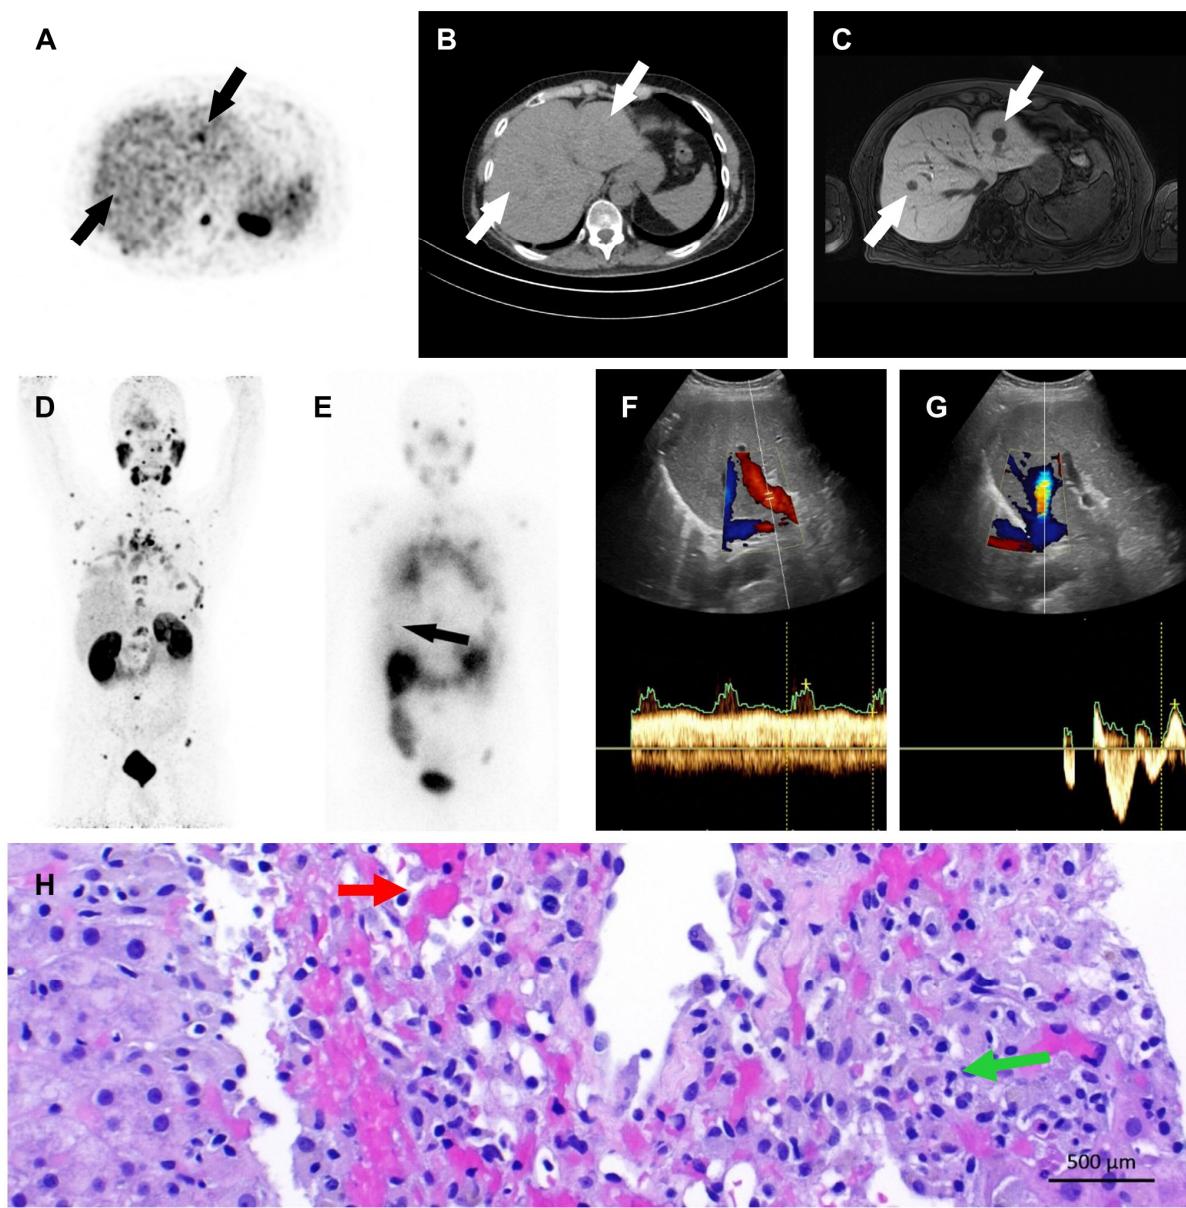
(A)-(C): Axial views of liver lesions: ^{68}Ga -PSMA PET/CT, contrast enhanced CT and MRI (T1flash 20 min. after 7ml Gadoxetate disodium iv.) (from left to right). Arrows indicate liver metastases. The liver metastasis in the left lobe has very low PET-uptake (miPSMA2) while the other metastasis in the right lobe showed no uptake above the liver (miPSMA1). (D) 3D MIP of ^{68}Ga -PSMA PET/CT. (E): Post-therapeutic whole-body-scan in anterior view, black arrow is pointing to very low focal uptake within hepatic
